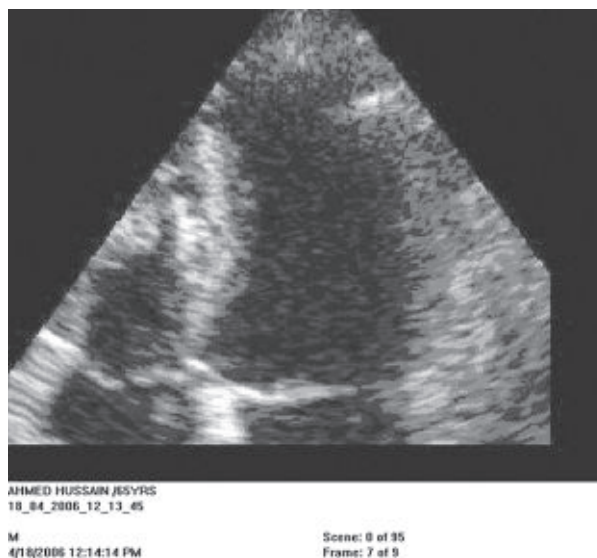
DSE in apical 4-chamber view.
